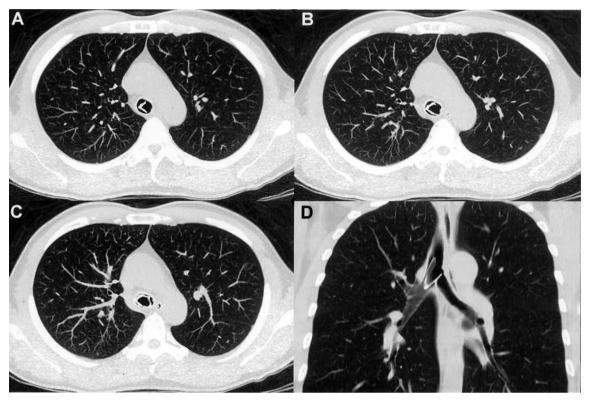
Chest CT scan with lung window settings. (A-C) On transverse sections, a cylinder-shaped calcified foreign body obstructing the lower trachea can be seen. (D) In the frontal reconstructed view, the foreign body extended from the lower trachea into the right main bronchus.
